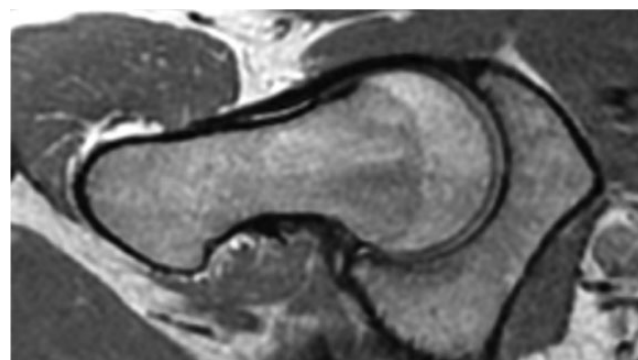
Magnetic resonance image of the right hip of a 19-year-old female control without any cam lesion.
